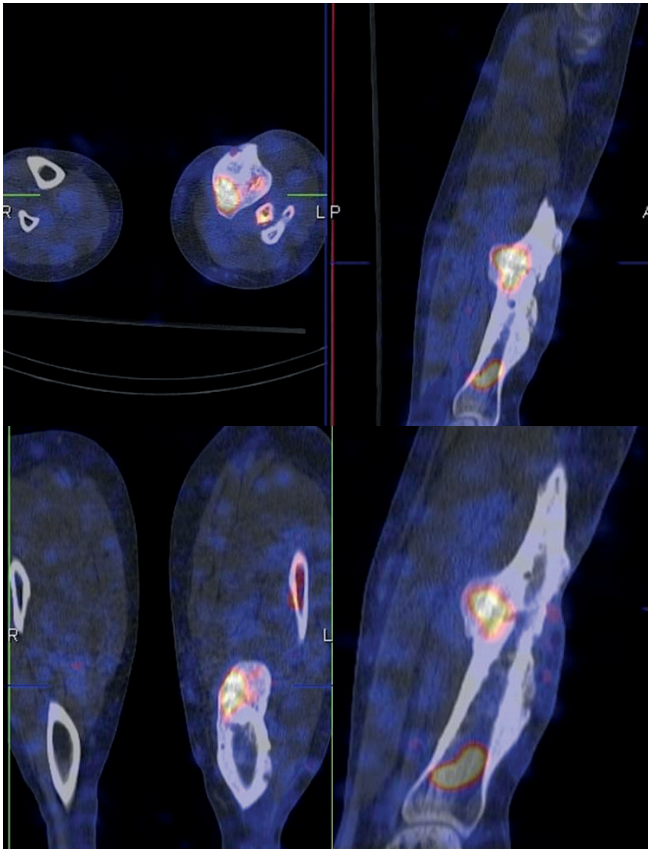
WBC SPECT-CT of patient C.
